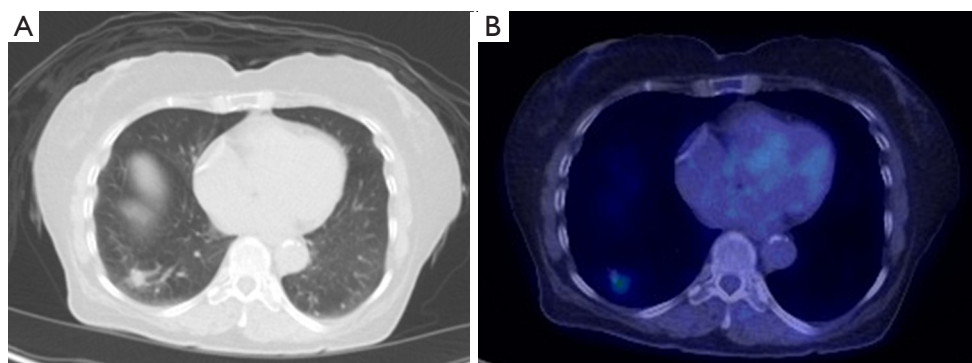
A 69-year-old man with a previous metastatic malignancy with enlarging right lower lobe pulmonary nodule (A). Fused axial images from ^{18}F -FDG PET/CT (B) demonstrate minimal FDG uptake. The pulmonary nodule was biopsied and was negative for malignancy but was consistent for focal organizing pneumonia.
